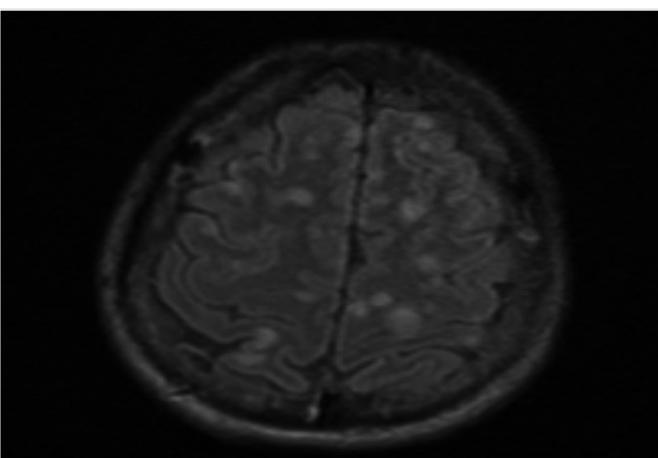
Axial T2-FLAIR images showing hyperintense lesions with edema at the corticomedullary junction and in the centrum semiovale
